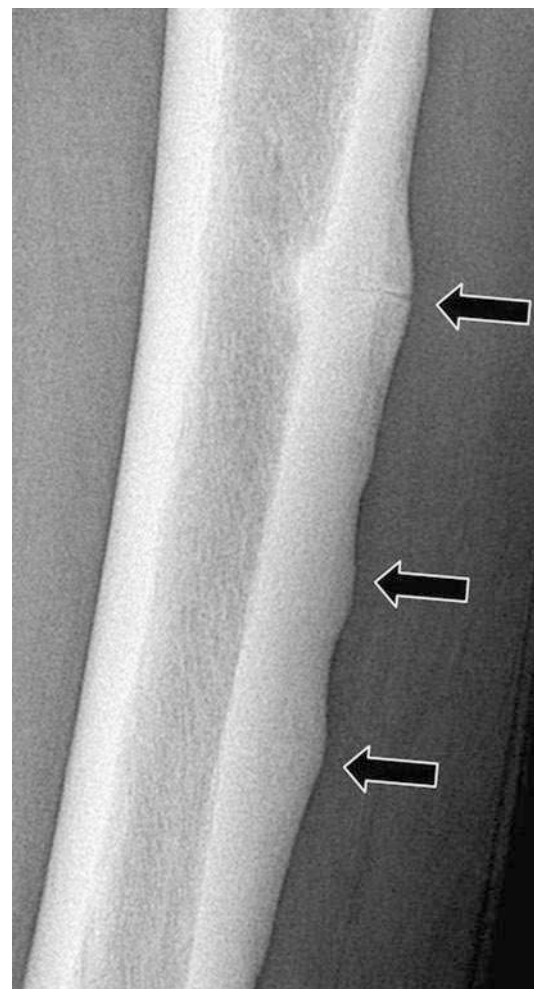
A radiograph of the left femur of a 80-year-old woman on bisphosphonate therapy since 12 years demonstrates multiple transverse partial cortical fractures (*arrows*)
